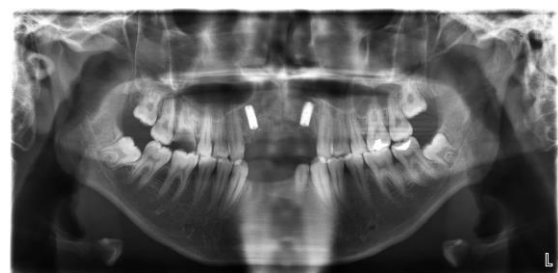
6 month post operative radiographic view
